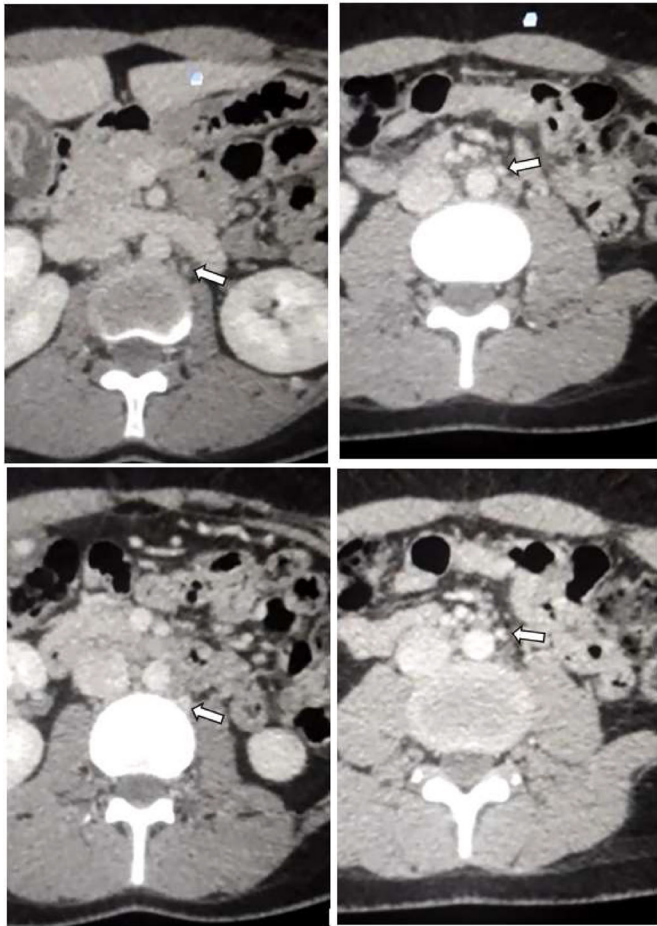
CT images demonstrating multiples para-aortic lymph nodes, the largest measuring 7 mm (Solid arrows).
